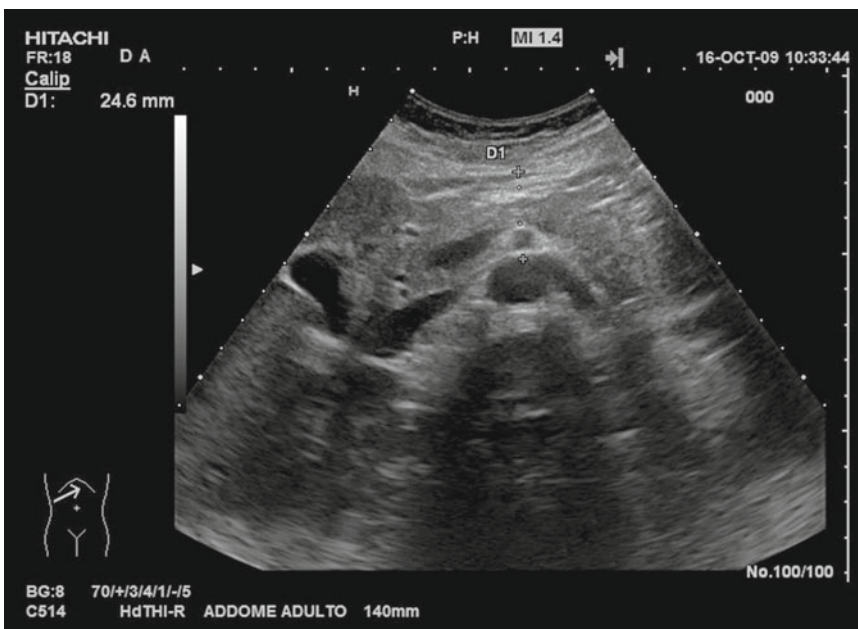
Transverse sonogram just above the center of the xypho–umbilical line displays the visceral fat measured between the posterior aspect of the abdominal wall and the anterior wall of the abdominal aorta
